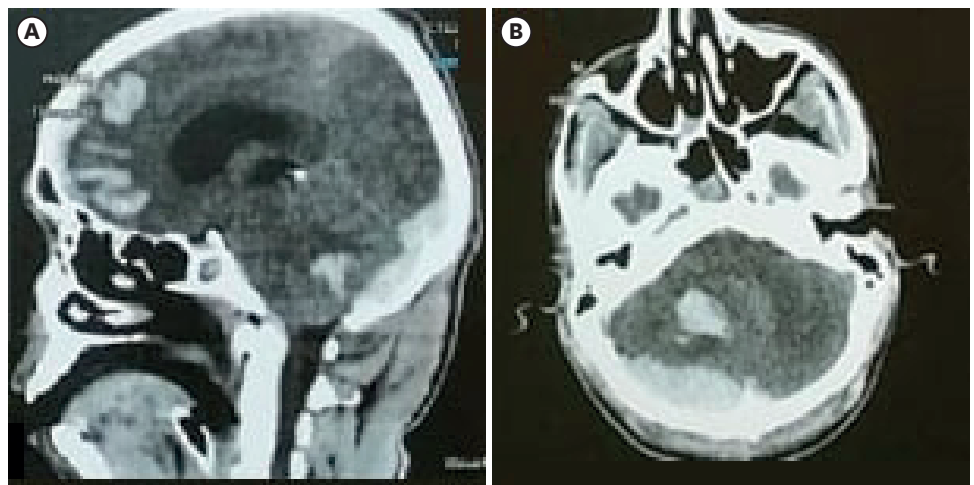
Initial CT scan (case 3). Sagittal (A) and axial (B) sections of a brain computed tomography scan showing multiple post-traumatic intracranial lesions including a supratentorial infratentorial epidural hematoma, right cerebellar and frontal contusions. The lesions developing within the posterior fossa were responsible for an upward hydrocephalus.
